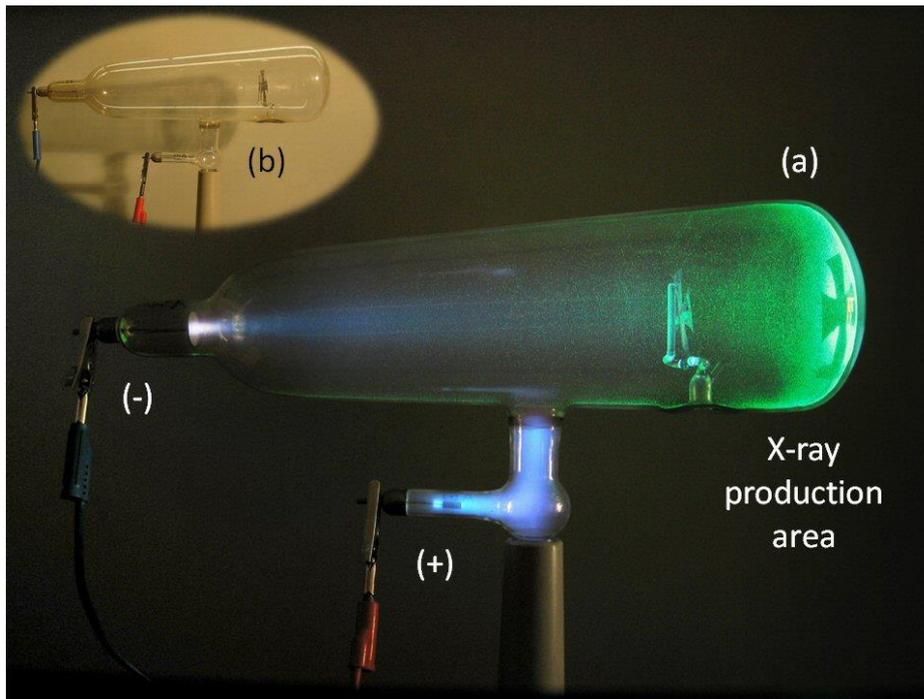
Crookes tube with shadow cross in use. X-rays emerge upon impact of electrons (cathode rays) on the glass wall at the right. Sub-picture: the uncharged tube. (Credit: D-Kuru, <https://commons.wikimedia.org/w/index.php?curid=3068002>, accessed Aug. 10th, 2017.)
